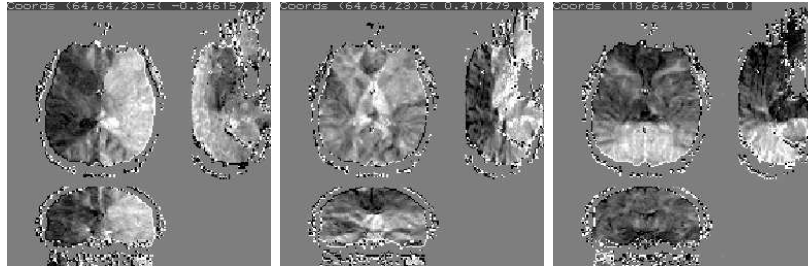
Diffusion MRI: Gradient $\text{grad}\phi$ of the distance function on M
